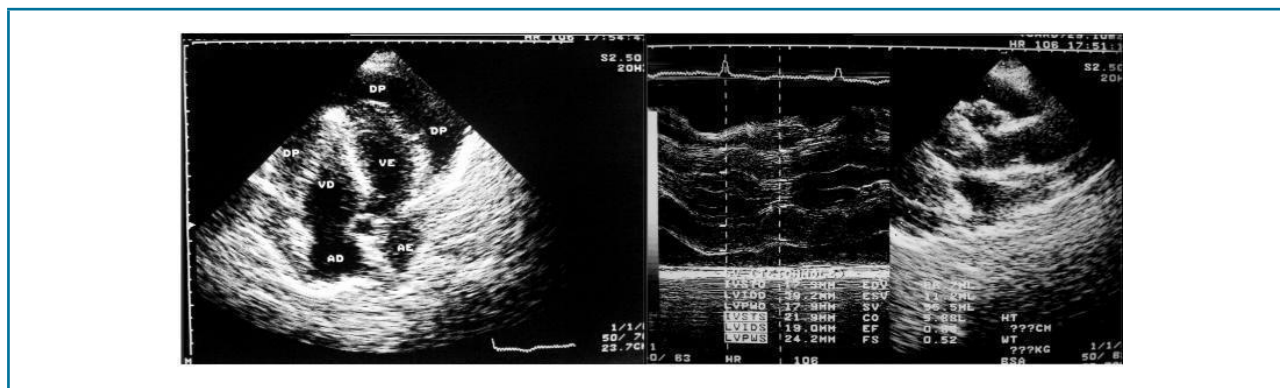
Echocardiogram showing marked increase in myocardial thickness. Belém, Pará, Brazil, 2022.
